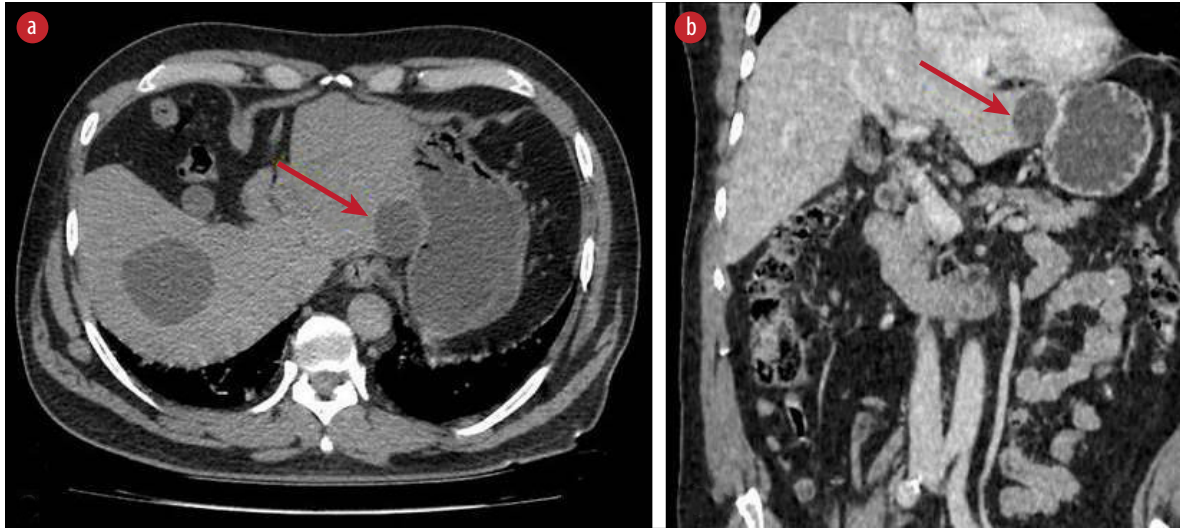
Abdominal computed tomography (a) axial and (b) coronal views showed a simple hepatic cyst of the left lobe that compressed the stomach wall (red arrows).
